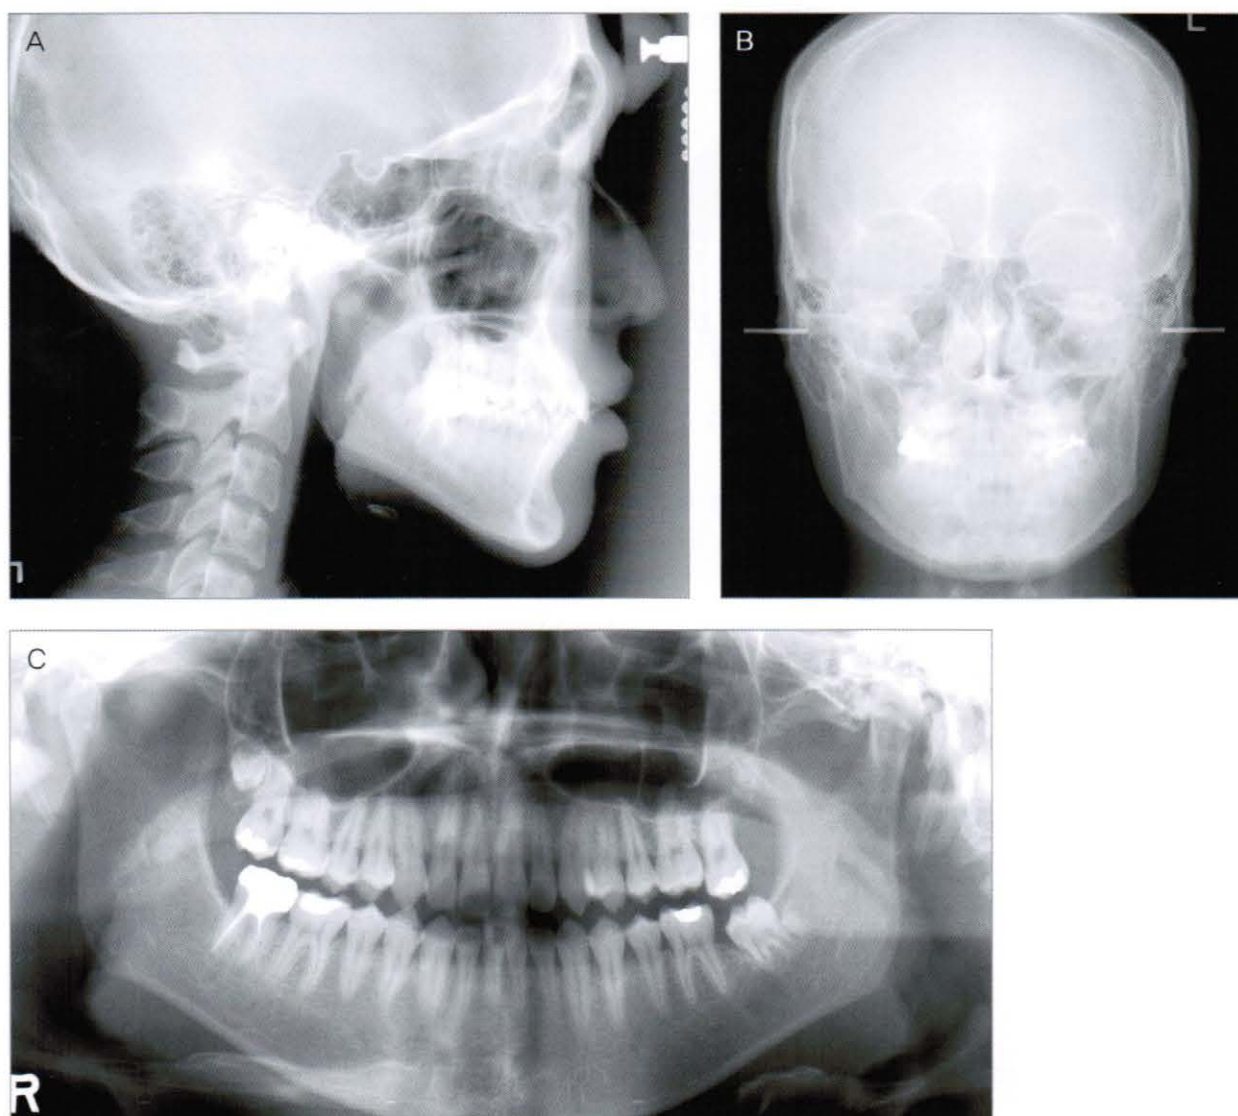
Pre-treatment cephalometric radiograph (A), postero-anterior radiograph (B), and panoramic radiograph (C) (2006, 1,3)
